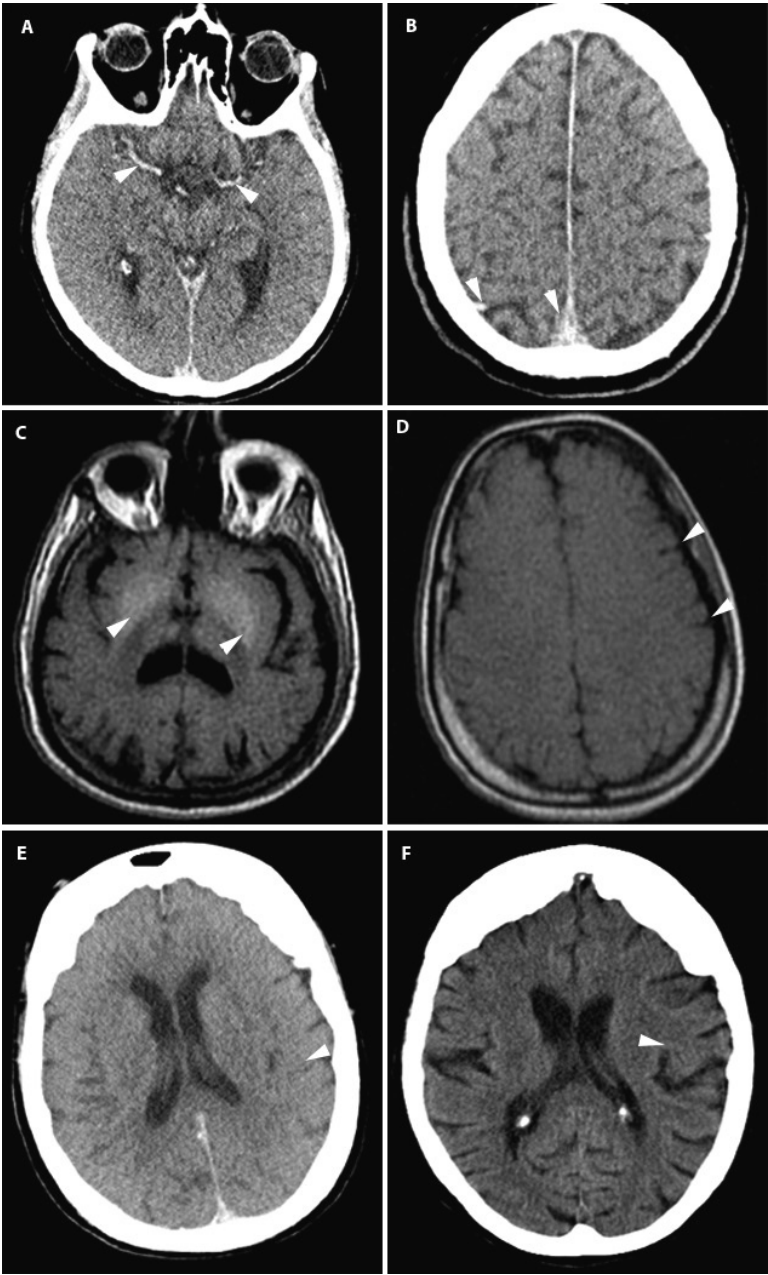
Postmortem imaging features of the brain. (A) PMCT: Symmetrical hyperdense cerebral arteries (arrowheads). (B) PMCT: Hyperdensity in the dependent cerebral veins and sagittal sinus (arrowheads). (C) T1w PMMR: High signal of the basal nuclei of the brain (arrowheads). (D) T1w PMMR: Sulcal effacement (arrowheads). (E/F) PMCT (E) and antemortem CT (F) of the same patient. The antemortem CT scan shows normal grey-white matter differentiation (arrowhead). PMCT shows complete loss of grey-white matter differentiation (arrowhead).
